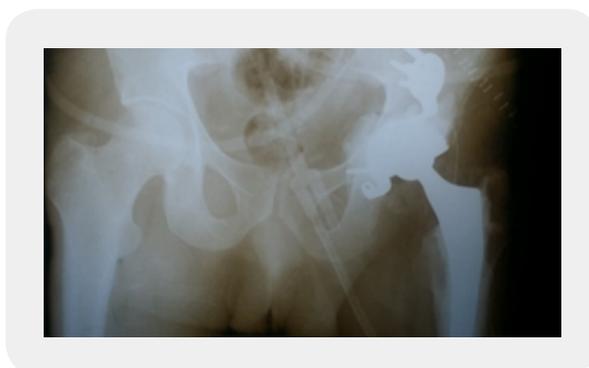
Immediate post-operative X-ray showing reconstruction of acetabulum using impaction bone graft*
